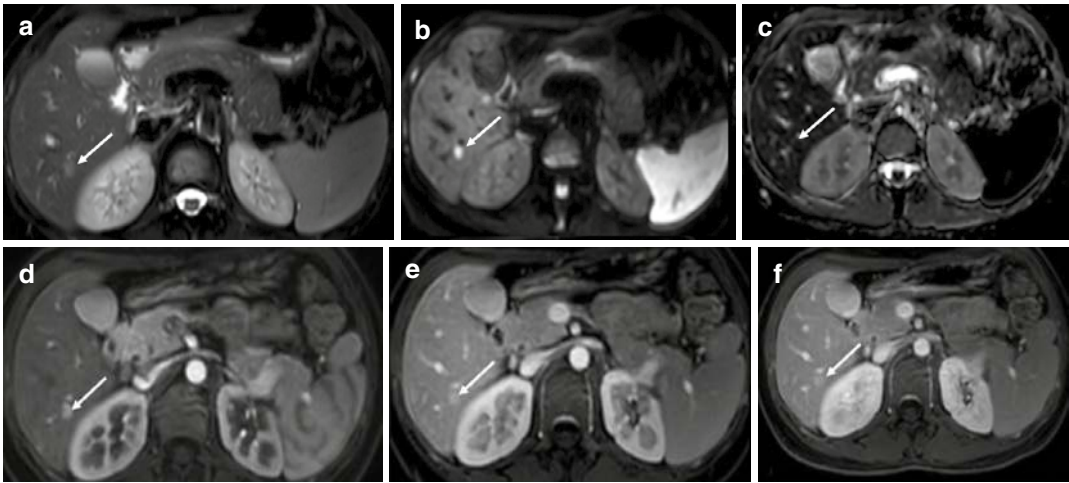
A 27-year-old female with a high-grade dysplastic nodule/early HCC. (a) Axial T2-weighted MRI showed a hyperintense nodule in segment VI of the liver (arrow). (b, c) Axial high b-value (b=800) diffusion-weighted MRI (b) showed a hyperintense signal of the nodule with corresponding hypointensity on the ADC
